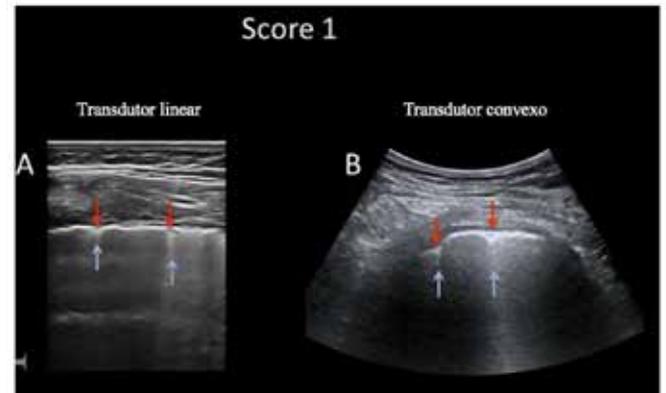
Pulmonary ultrasound images obtained with a linear (A) and convex (B) probe. The pleura line is not continuous. Below the point of discontinuity (indicated by the red arrows), vertical white areas are visible, or B lines (indicated by the blue arrows). This standard is classified as Score 1⁶.
